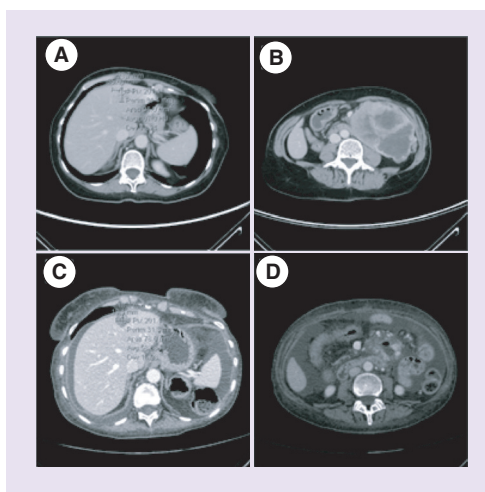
Disease evaluation 1 month after starting imatinib. (A & B) Basal CT scan performed in June 2013. (C & D) CT scan performed 1 month after starting imatinib showing a reduction in the size and average density of the primitive gastrointestinal stromal tumor associated with a decrease in the number, size and average density of the liver metastases.
